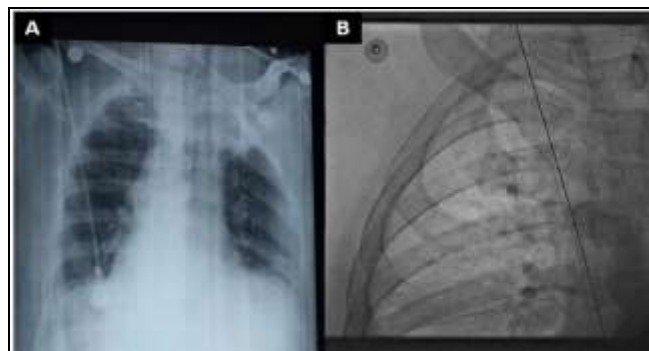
Central Venous catheter (CVP) Guidewire location on Chest X-Ray (A) and Fluoroscopy (B)
